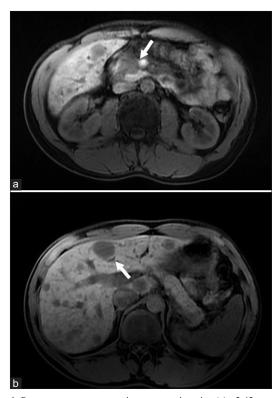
Pancreas contrast magnetic resonance imaging (a) a 2.42-cm mass in the pancreatic head (white arrow), suspected adenocarcinoma of the pancreatic head. (b) Multiple nodules in both lobes of the liver, and the maximal size (white arrow) was approximately 2.7 cm
